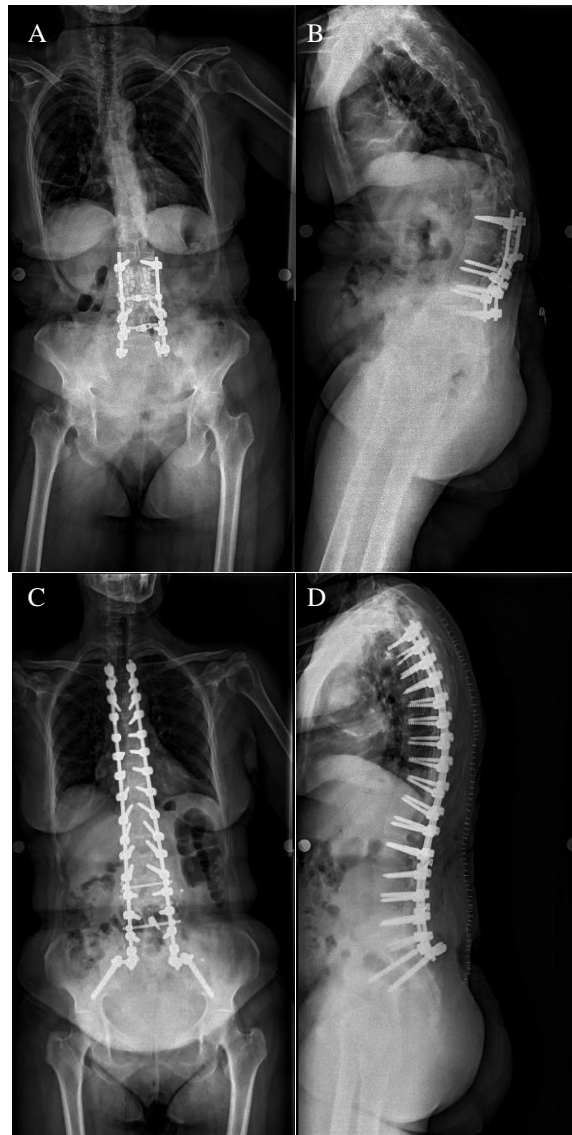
Anteroposterior and lateral X-ray view of kyphosis deformity developing after the operation due to spinal stenosis (A, B). To correct the deformity, the patient underwent instrumentation and 3 levels of Ponte osteotomy between the thoracic 3rd vertebra and the iliac wing. A cannulated iliac screw was used for the iliac wing detection (C, D).
